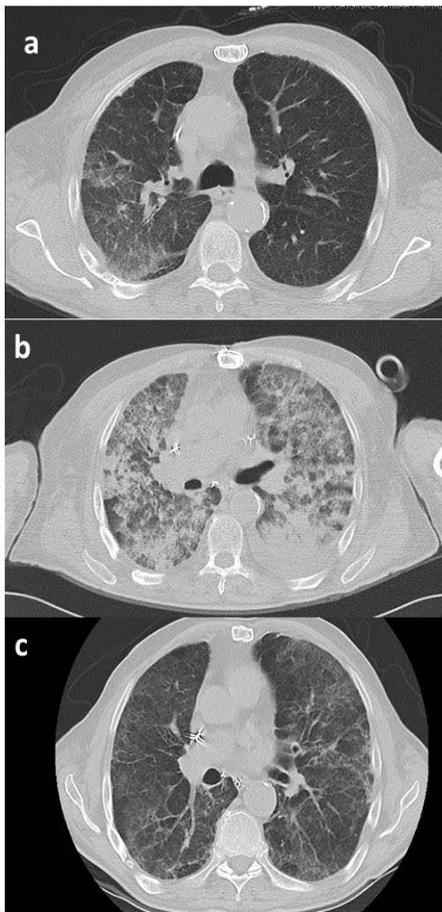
Contrast-enhanced computed tomography scan at admission (a), 8 days after admission, showing thickening of interlobular septa, massive diffuse alveolitis with extensive patchy and confluent ground glass opacities in both lung fields (b) and 15 days after admission (seven days after starting steroid and immunoglobulin therapy) showing significant clearance of previous pulmonary findings (c).
